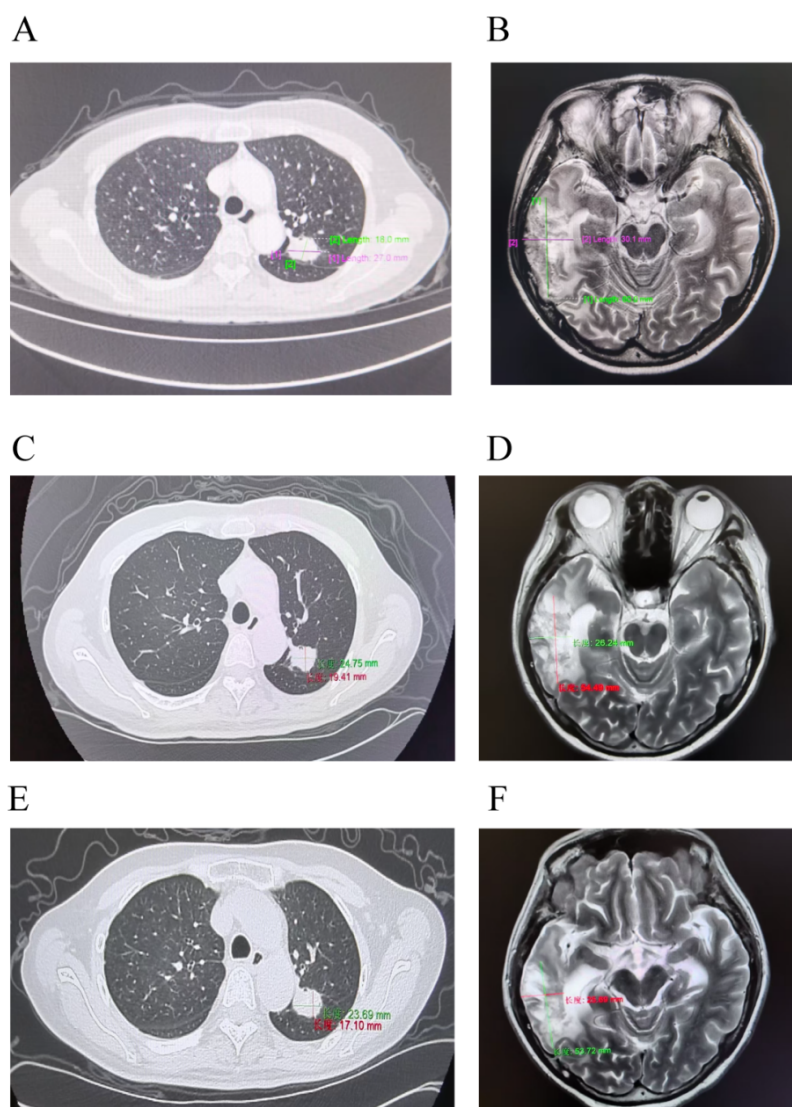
Follow-up imaging of lung and brain lesions in EGFR-mutant NSCLC treated with zorifertinib + firmonertinib combination therapy. (A) Chest CT before combination therapy. (B) Brain MRI before combination therapy. (C) Chest CT on 30 April 2025, stable pulmonary lesions at 3-month follow-up. (D) Brain MRI on 29 April 2025, residual leptomeningeal enhancement at 3-month follow-up. (E) Chest CT on 30 June 2025, continued stable disease at 5-month follow-up. (F) Brain MRI on 1 July 2025, further reduction of sulcal enhancement at 5-month follow-up. CT: Computed Tomography; LM: leptomeningeal metastasis; MRI: Magnetic Resonance Imaging.
